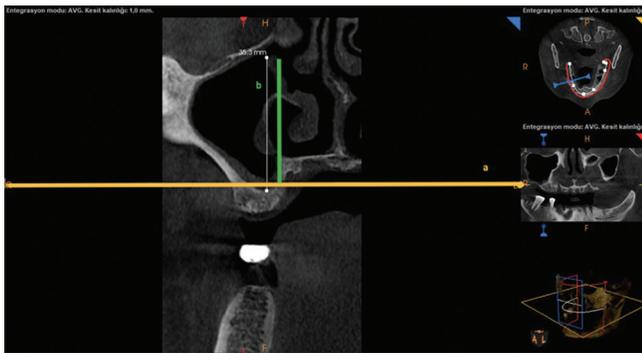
Height measurements in the coronal slices of a CBCT image [with the guiding horizontal line (a) and perpendicular vertical line (b)]
